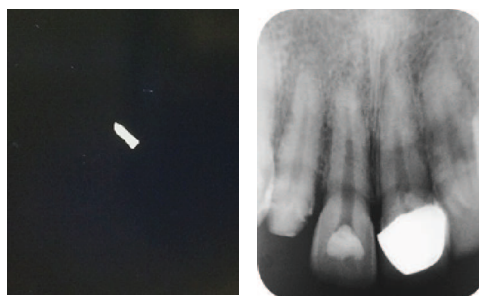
Preoperative periapical radiograph showed open apices and radiopacity at the coronal third of tooth 11.
